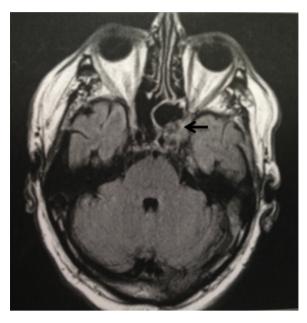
Cerebral magnetic resonance imaging on T2 FLAIR-weighted: isosignal and heterogeneous mass involving the left cavernous sinus (black arrow).
